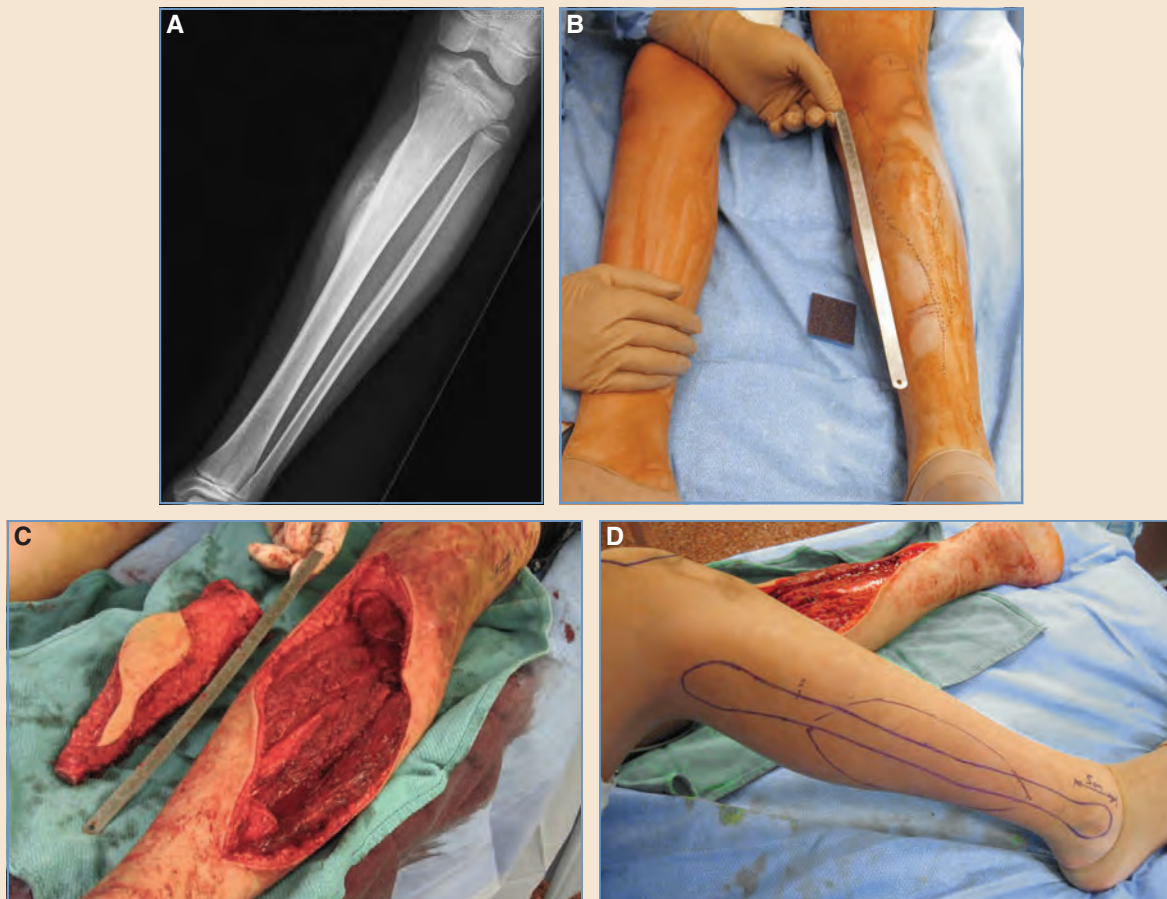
This case shows the role of an osteocutaneous fibula flap for reconstruction after excision of an extensive tumor of the tibia. A, A reoperative radiograph of a tumor amenable to intercalary resection. B, Intraoperative planning involved measuring the length of fibula required. C, The tumor was excised, and the defect was extensive. D, An osteocutaneous fibula flap was marked.
